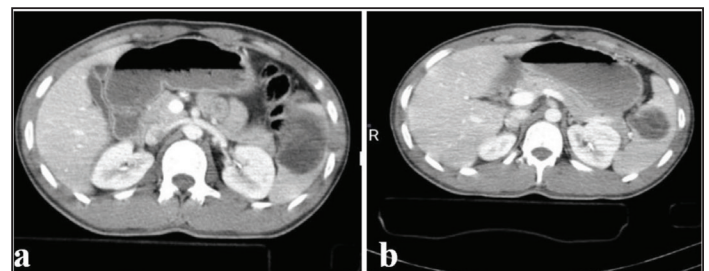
Abdominal pelvic CT scan revealing splenic cyst at admission.
